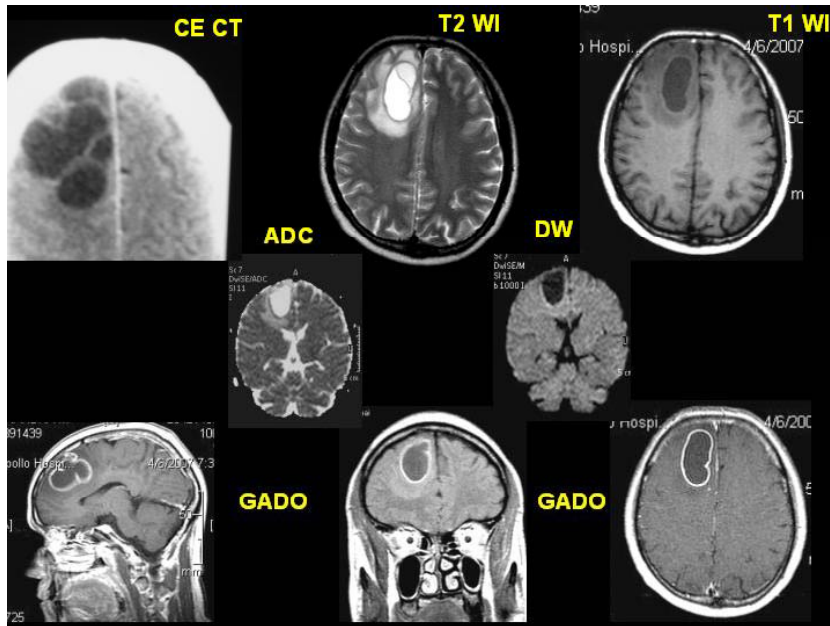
MRI shows multi-loculated, enhancing thinwalled, cystic lesion in the right frontal lobe; lesion displays non-restricted area on DWI suggestive of infected cyst.
